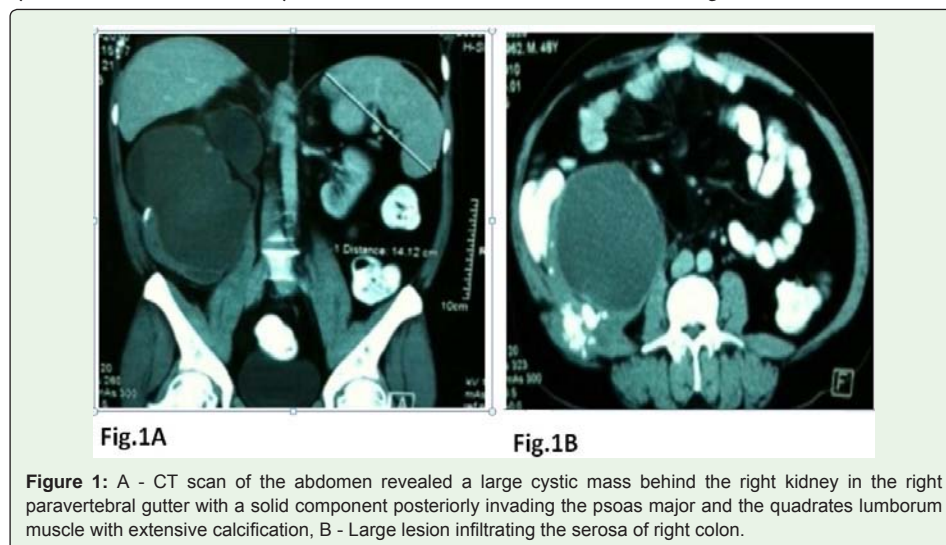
A - CT scan of the abdomen revealed a large cystic mass behind the right kidney in the right paravertebral gutter with a solid component posteriorly invading the psoas major and the quadrates lumborum muscle with extensive calcification, B - Large lesion infiltrating the serosa of right colon.
